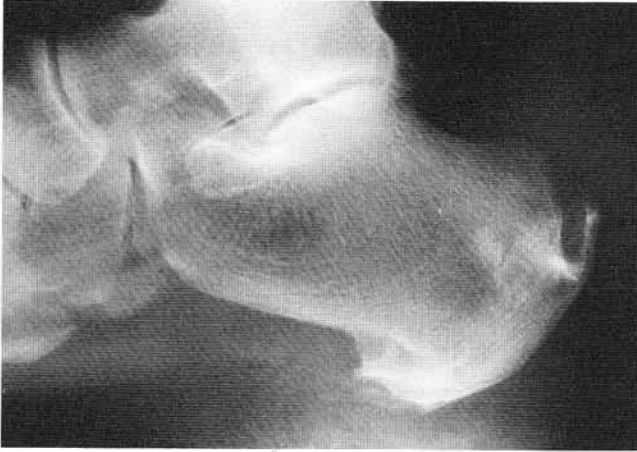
Preoperative radiographic appearance of a patient with a large retrocalcaneal exostosis and spur.
